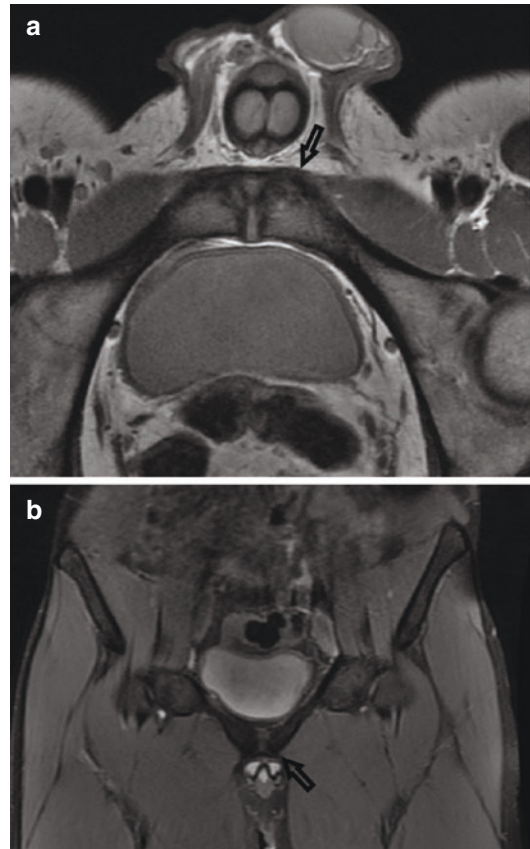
MRI of osteitis pubis. Axial image of a 21-year-old soccer player shows (a) left osteitis pubis with the widening of the pubic symphysis and (b) shows subchondral edema of the left pubic bone
